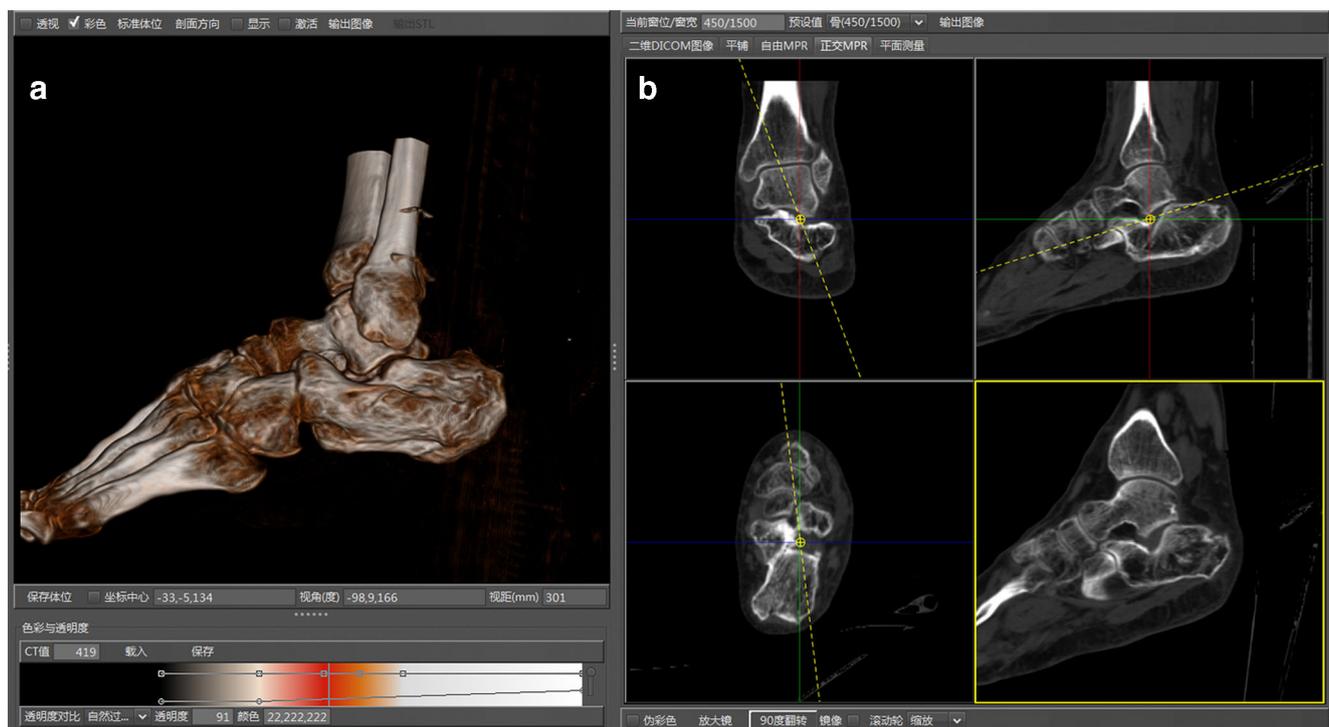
The pre-operative CT for analyzing injury details. a The 3-D image of the malunited calcaneus fracture was reconstructed by volume rendering. b The 2-D images were reconstructed by multiple planar reconstruction, which could detect the congruity of subtalar joint with or without arthrosis
